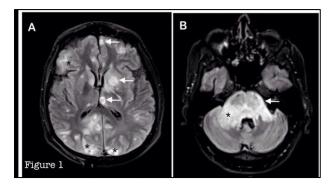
Axial T2 FLAIR (Fluid attenuated inversion recovery) MRI images (A and B) show multiple hyperintense lesions involving bilateral basal ganglia, thalami, cerebral cortico-medullary junction, subcortical white matter and brainstem (shown by arrows) with significant perilesional vasogenic oedema (shown by asterisk) and mass effect resulting in effacement of ventricles.
